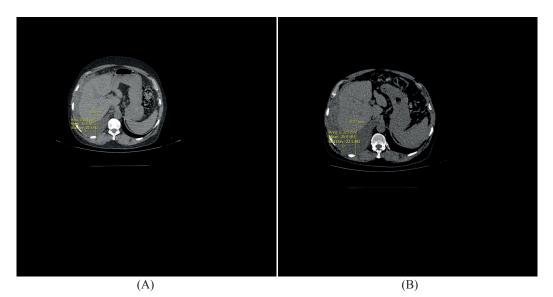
(A) CT peritoneography demonstrating hydrothorax at D12 level: 0 hour image with intra-pleural width 4.5 cm and CT value 15-HU. (B) CT Peritoneography demonstrating hydrothorax at D12 level: 4-hr delayed image showing an increase in intra-pleural width to 6.3 cm and CT value 35-HU.
